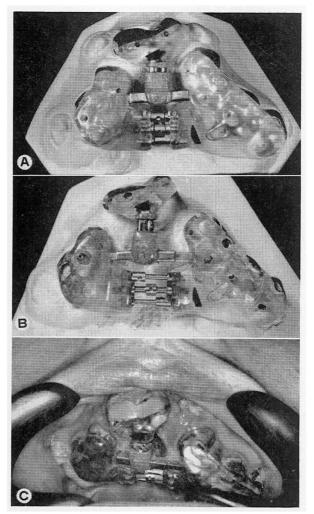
Case II: bilateral cleft. (a) Splint on model before expansion. (b) Splint on model after expansion. (c) Splint in situ after expansion. (d) X-ray films of splint before and after expansion. (e) X-ray films before expansion and after expansion and insertion of bone graft. (f) Articulated models before and after expansion. (g) Bite before expansion. (h) Bite after expansion.
